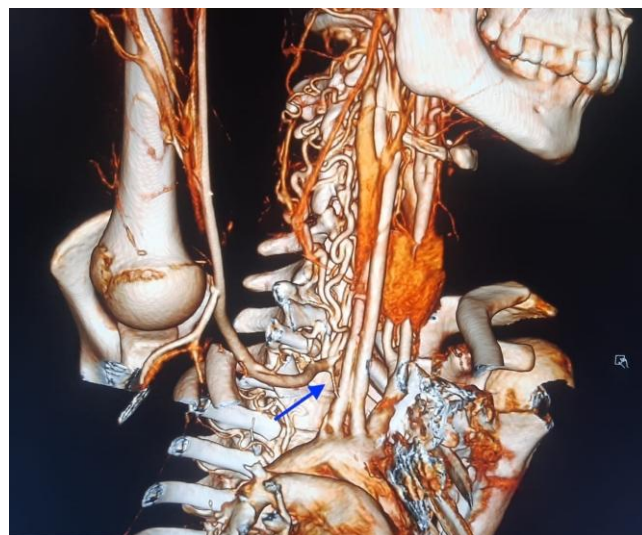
CTA 3D reconstruction
